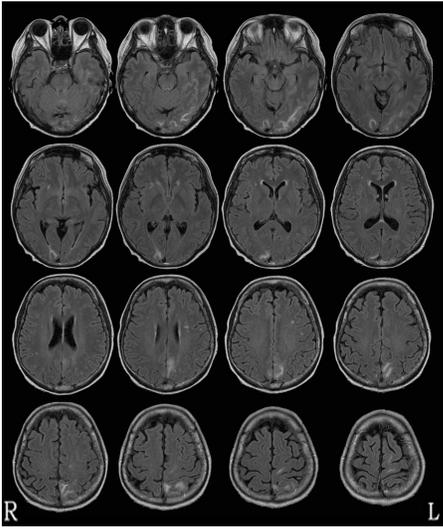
MRI scans of patient ES
